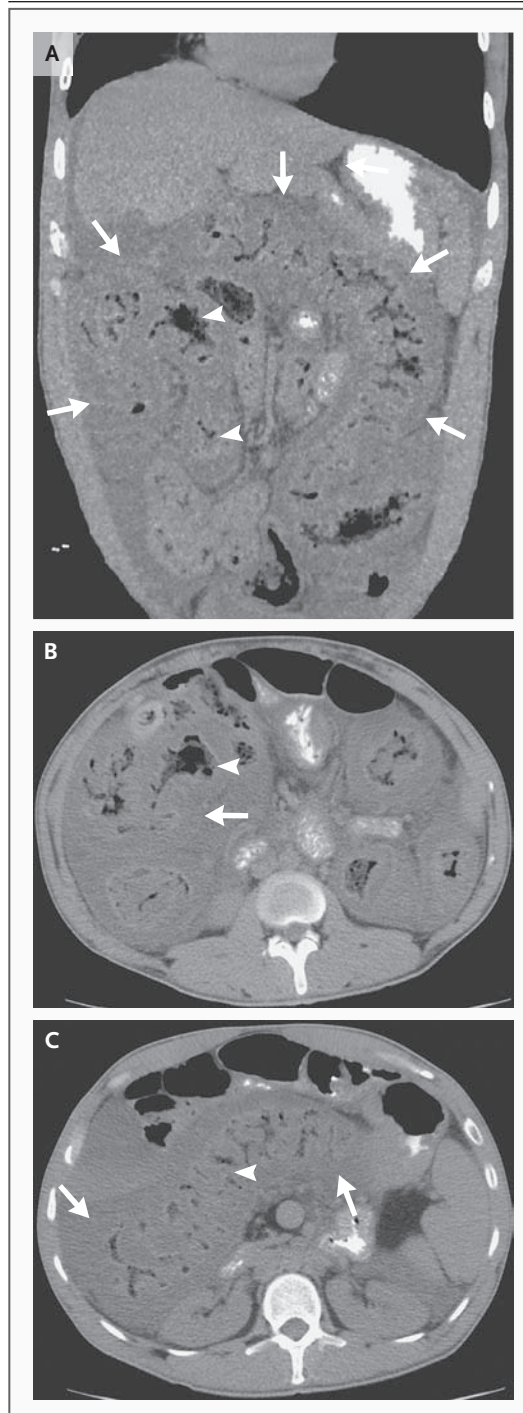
CT Scan of the Abdomen Obtained after the Administration of Oral Contrast Material on Hospital Day 8.
